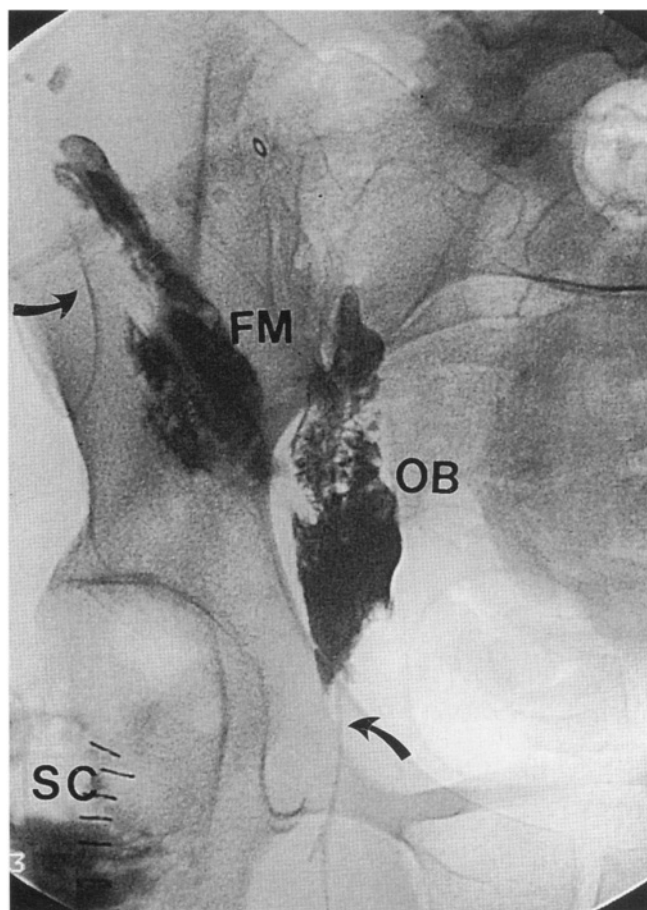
Radiograph following a hip disarticulation. Epineural catheters were placed within the nerve sheaths prior to wound closure. Contrast dye was injected to show the distribution of local anesthetics along the nerve sheaths. (SC = sciatic nerve, FM = femoral nerve, OB = obturator nerve). This patient was pain free postoperatively. Epineural catheters are not removed until the 5th postoperative day.
